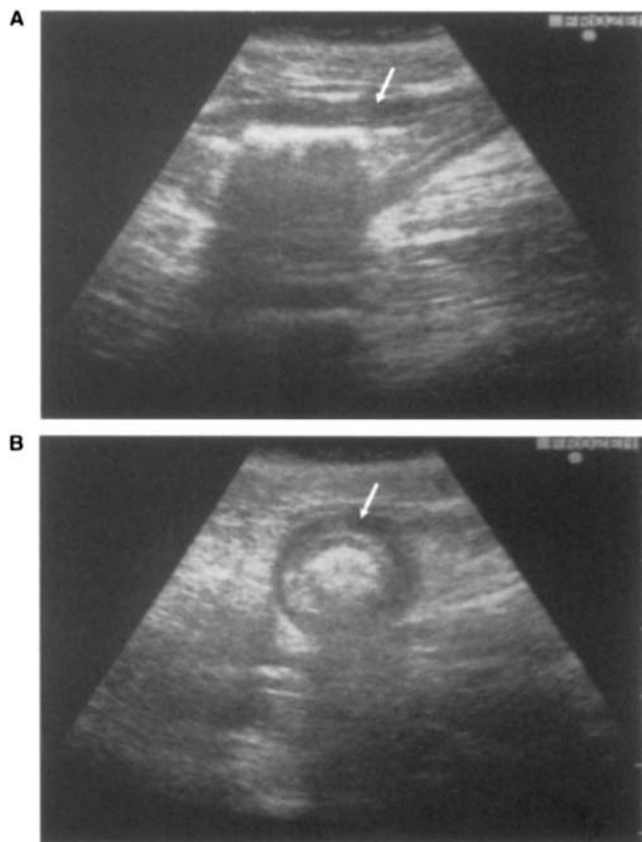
Sagittal (A) and transverse (B) ultrasound images of the small intestine. Note the central hyperechoic structure and acoustic shadowing due to an intestinal foreign body (rubber tube). Maintained intestinal layering and increased thickness of the muscular layer (arrow) are also evident.
